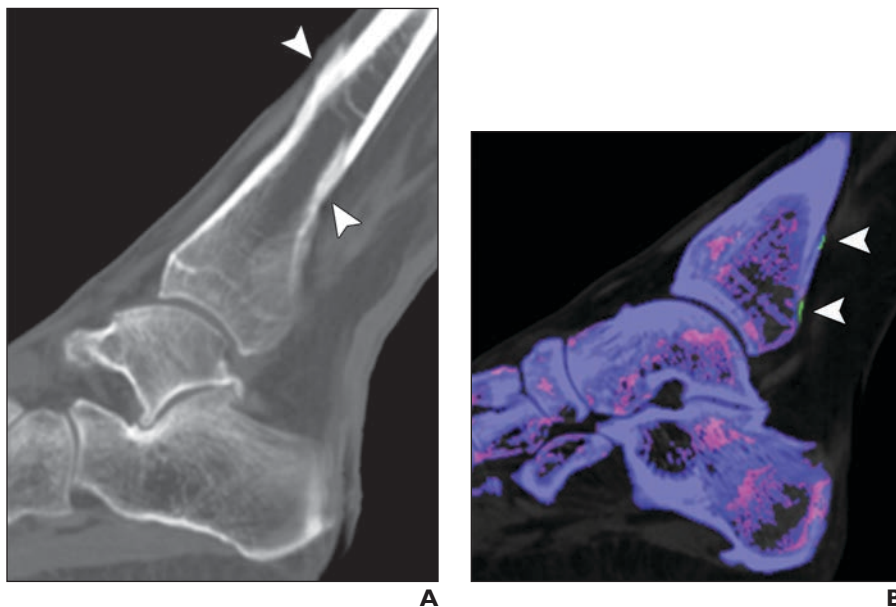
Likely arterial artifacts on dual-energy CT (DECT) images of 67-year-old man with suspected gout.
